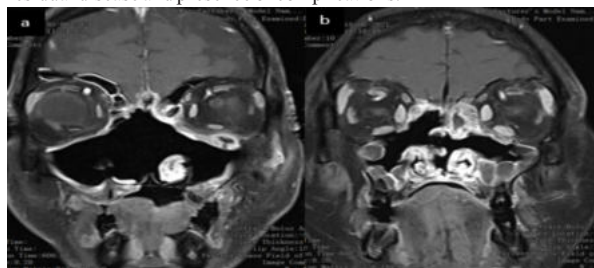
Post operative Follow up MRI postcontrast T1 coronal a)28
